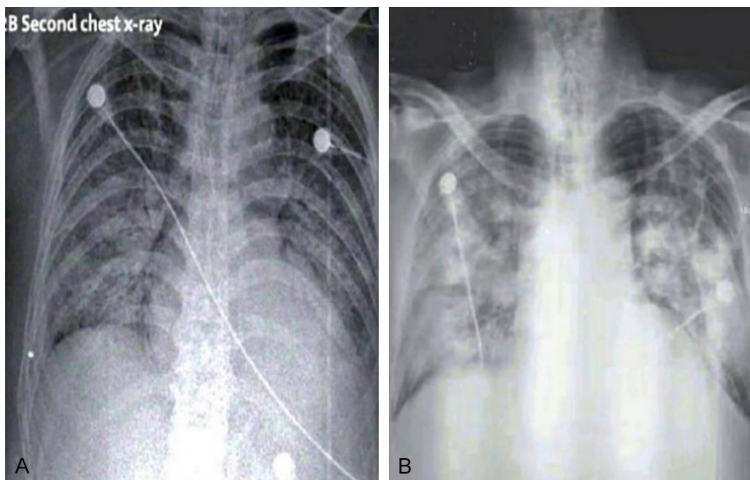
Chest radiographs of the patient. A: Before treatment; B: After treatment.
